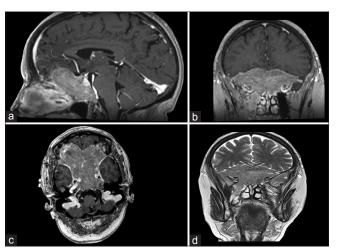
Preoperative sagittal (a), coronal (b), and axial (c) T1-magnetic resonance imaging showing slightly hyperintense and preoperative coronal (d) T2-magnetic resonance imaging showing isointense: anterior and middle skull base lesion with suprasellar extension, invading sphenoid sinus, clivus, ethmoid bone, anterior cranial fossa, and cavernous sinus extending in the right masticator space and encasing internal carotid artery
